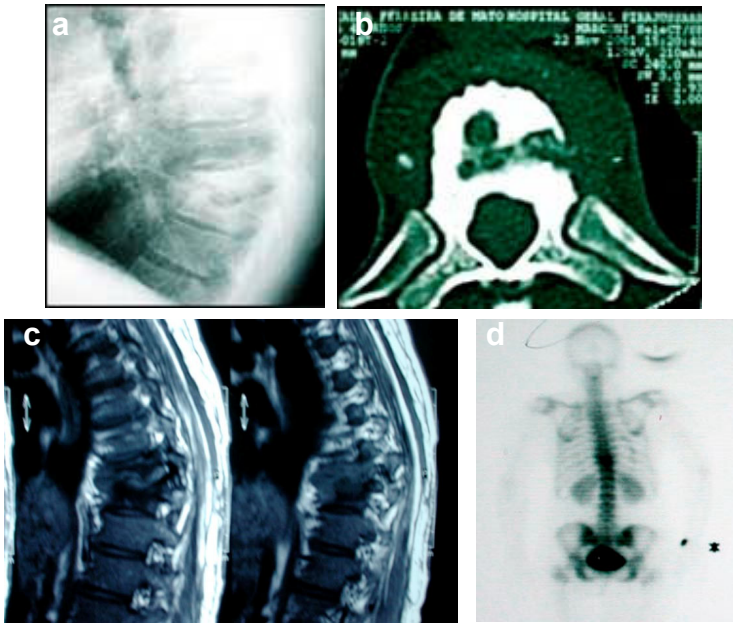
X-ray (a), computerized tomography scan (b), nuclear magnetic resonance (c), and scintigraphy (d) showing images of spondylitis and meningocele in a patient with Pott's disease (from the archives of Instituto Clemente Ferreira, Brazil)
